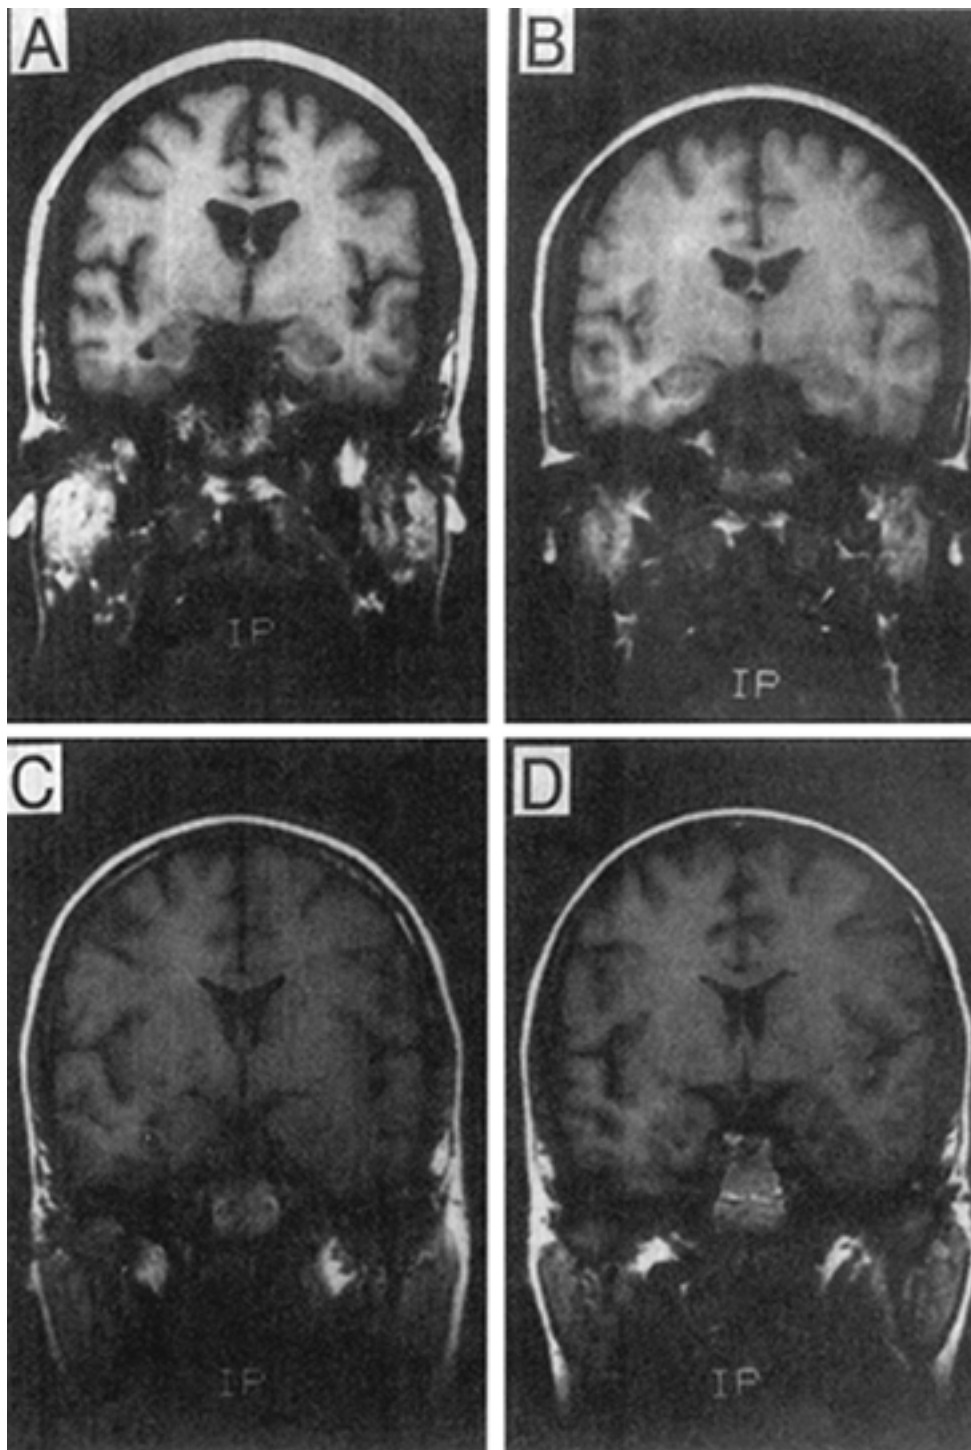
MRI scans (coronal sections) of two sets of discordant monozygotic twins (A and B = set 1; C and D = set 2). For each pair, one has schizophrenia (A and C) while the other does not (B and D). For both pairs, the affected twin has larger ventricles than the unaffected twin, even though ventricular size appears to be within the normal range for the affected twin (C). (Courtesy of D. Weinberger and E. F. Torrey.)
